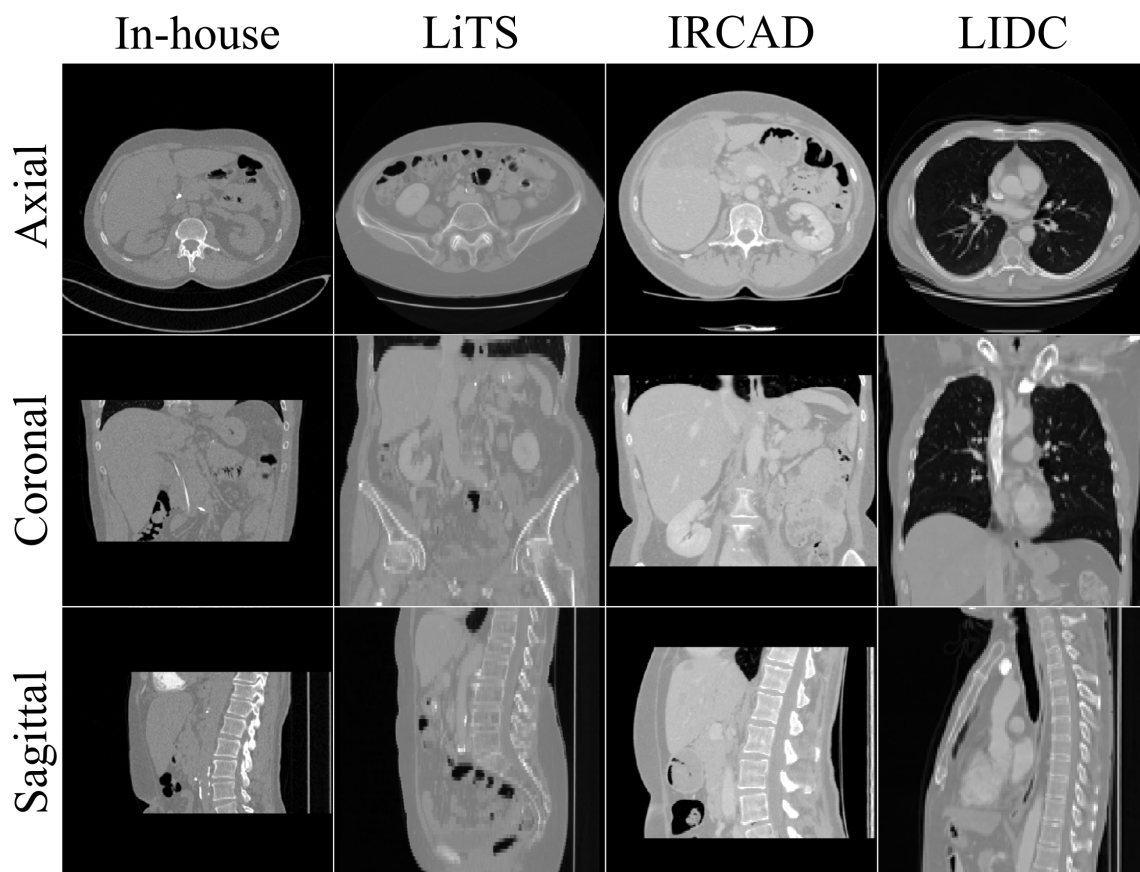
Overview of the clinical CT image data sets used in this thesis, one image is shown for each data set. From top to bottom row: Axial, sagittal, coronal views; each column corresponds to another CT image data set: in-house CT, liver tumor segmentation challenge (LiTS), 3D image reconstruction for comparison of algorithm database (IRCAD), Lung image database consortium image collection (LIDC).
